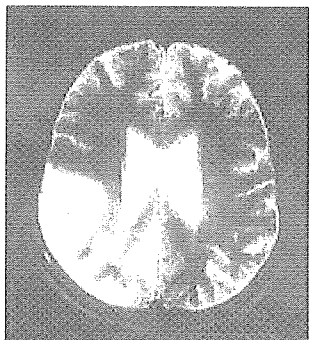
ミトコンドリア脳筋症(MRI T1強調画像)
